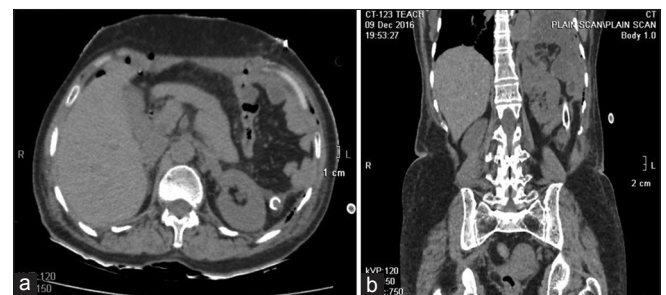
(a and b) Computed tomography abdomen done post-operative day 3 showed that the kidney was restored to its anatomical position
